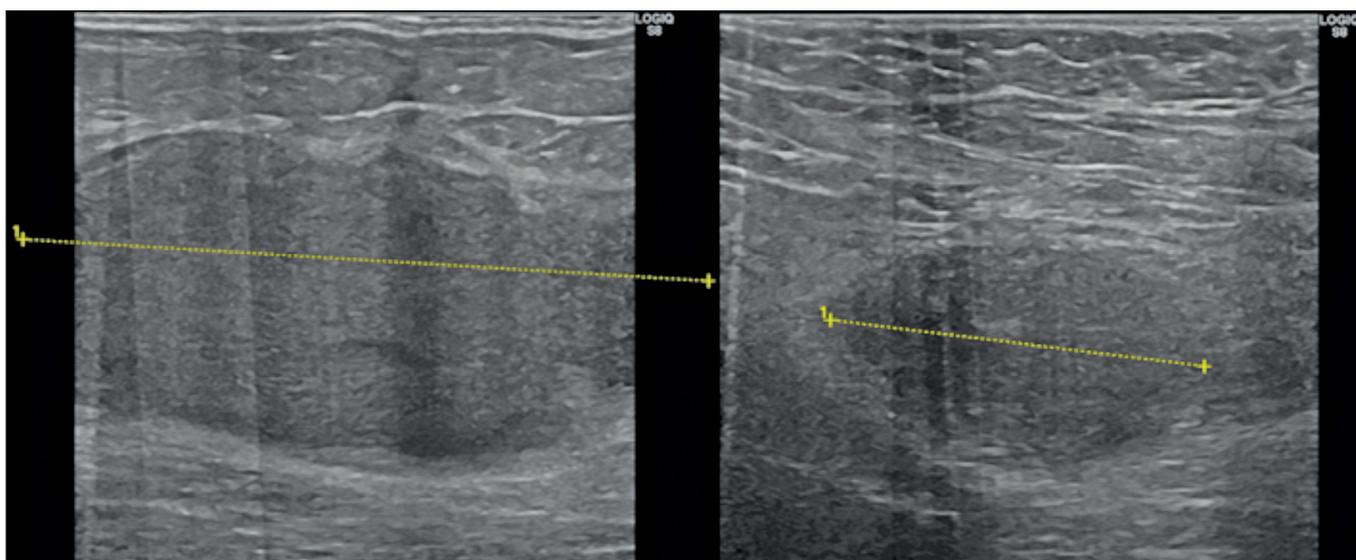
Right breast ultrasound on initial evaluation.
